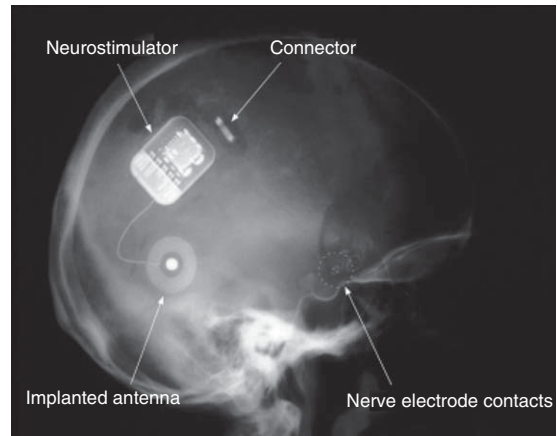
X-ray photograph of the implanted system. (Source: Reprinted from Veraart 2003.)
